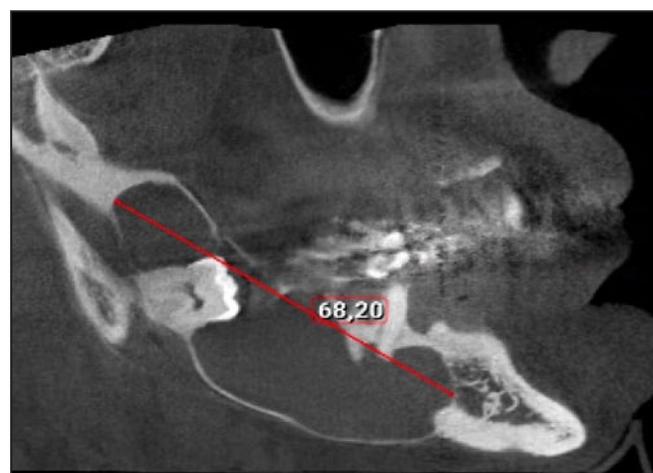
Preoperative cone-beam computed tomography showing measurement of ≈ 68 mm in anteroposterior dimension of the lesion.
